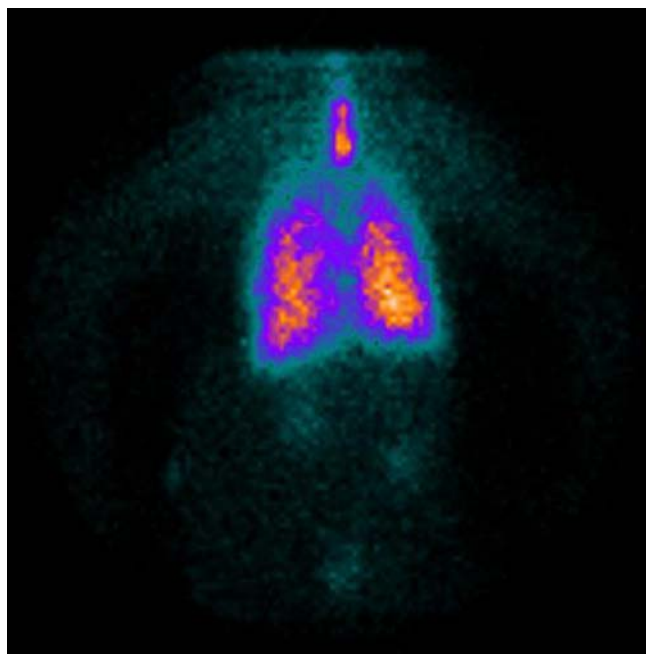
Lung scintigraphy (posteroanterior view) in baboon PP9513 after inhalation of gemcitabine with ^{99m}Tc -labeled DTPA using an Atomisor NL9M[®] breath-activated jet nebulizer
